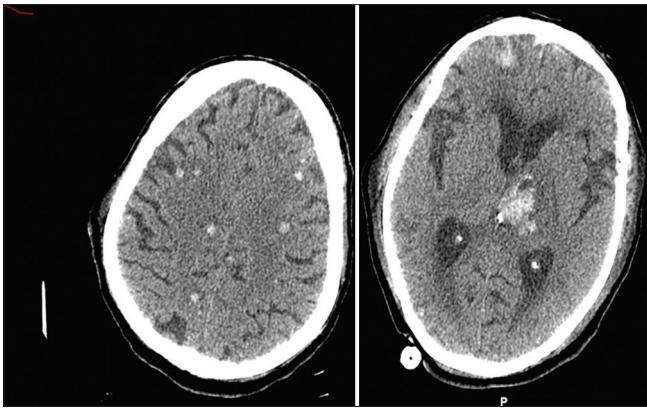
Non contrast computed tomography head shows multiple foci of cerebral hemorrhages, also involving the left thalamus
